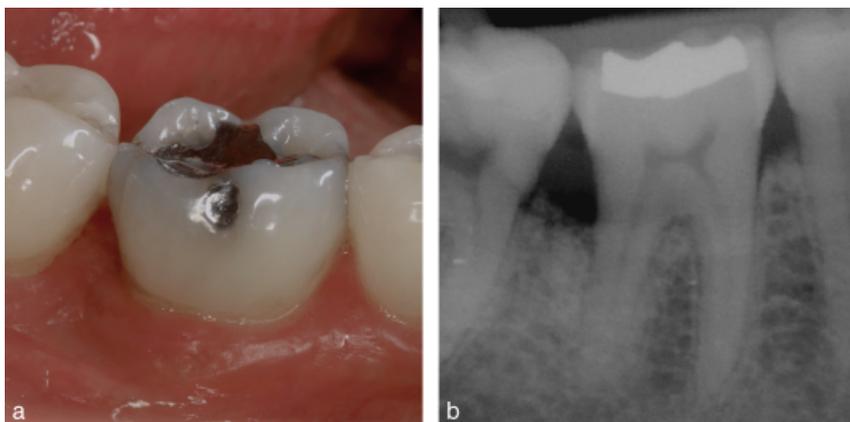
(a) The clinical result 6 years after treatment. Note the slight improvement in the soft tissue conditions when compared with the 1-year result. (b) Radiographically stable conditions are observed 5 years after treatment.
